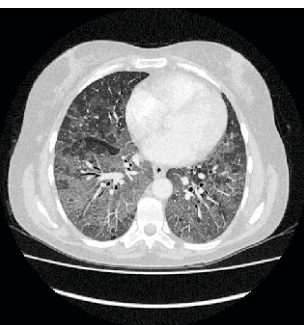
Chest CT scan in COVID-19.
